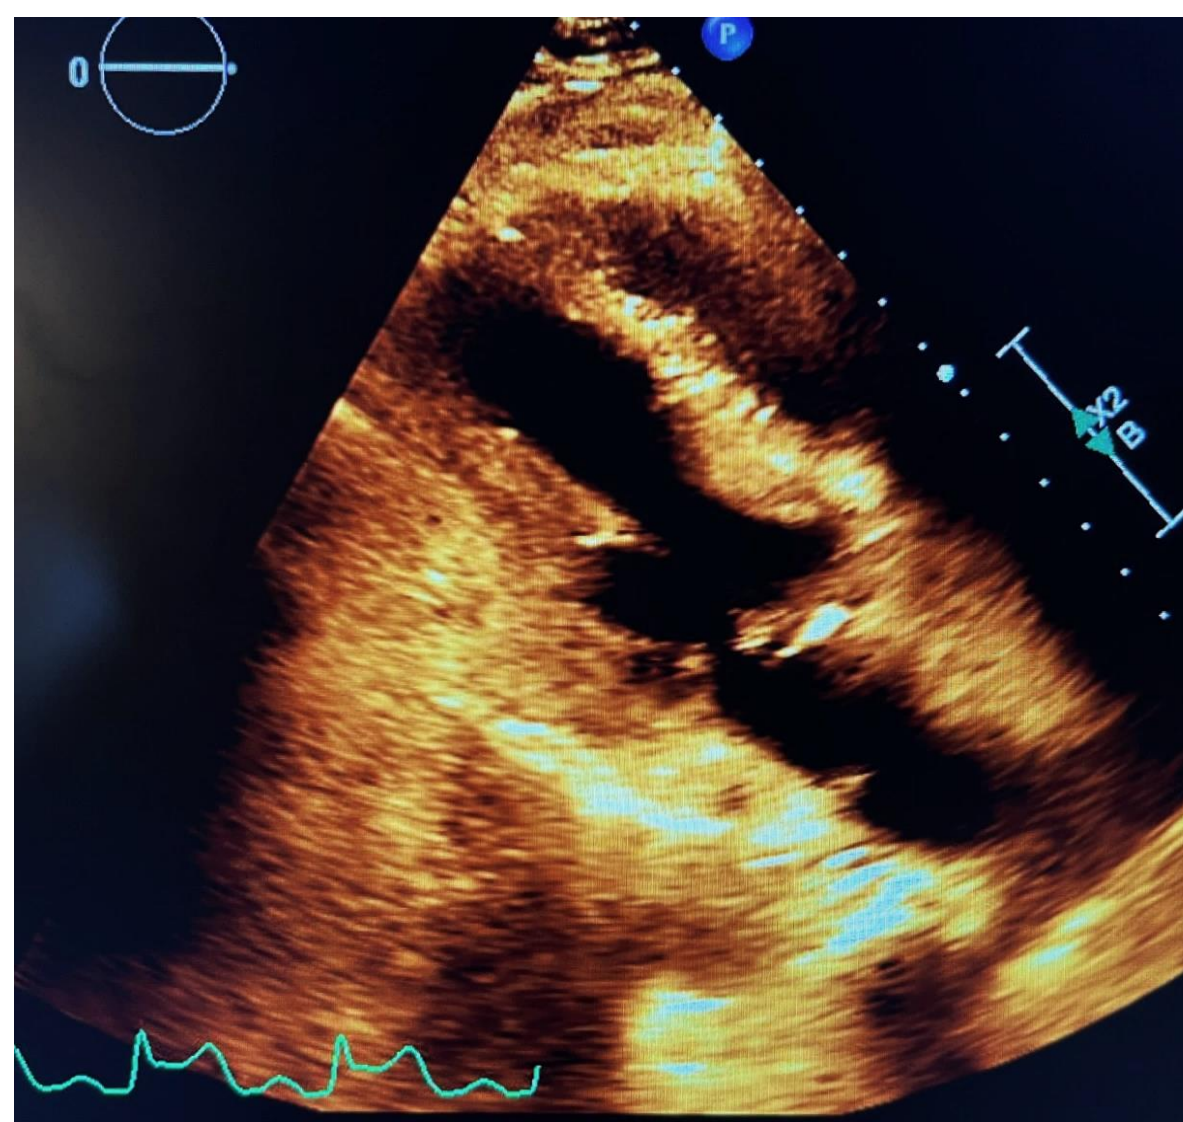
Transthoracic Echocardiogram (TTE)
